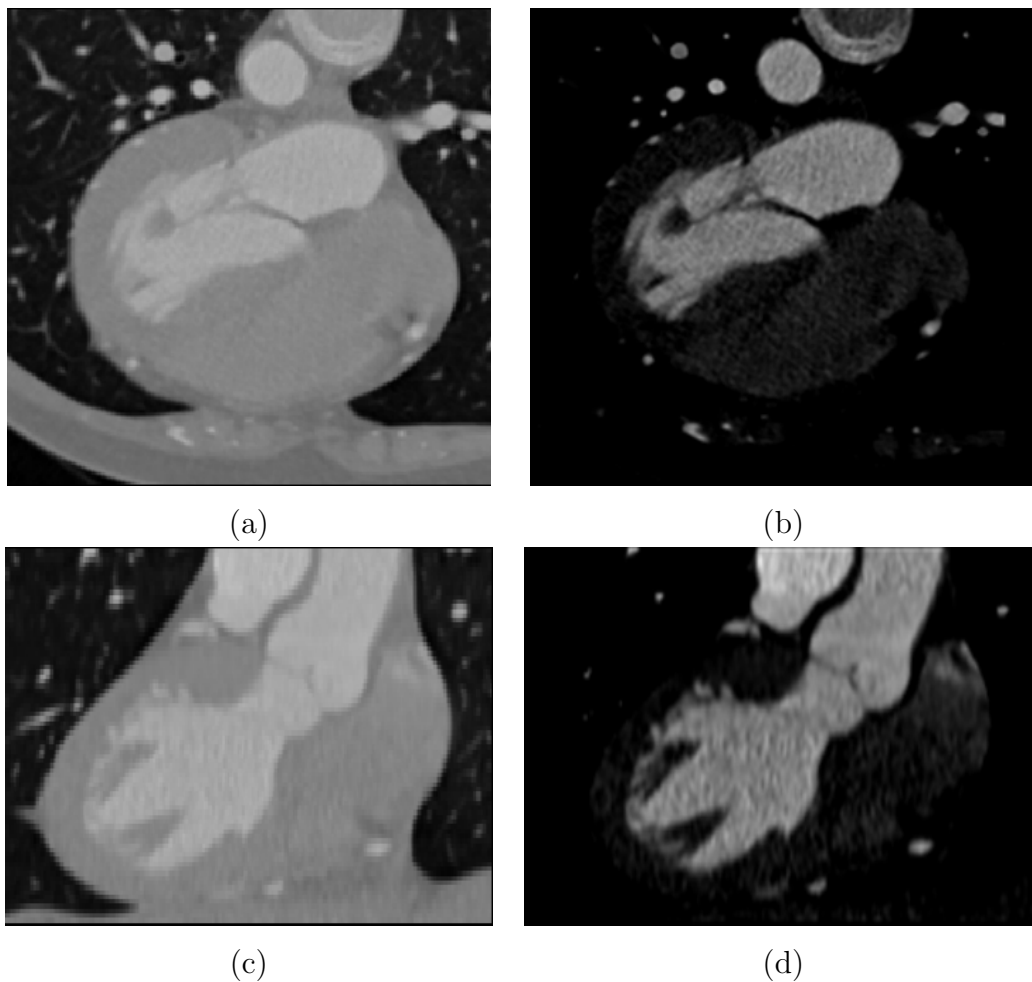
Example of an CTA image before and after pre-processing. (a) and (c): The original CTA image after contrast adjustment. (b) and (d): The post-processed CTA images showing better visibility of the coronaries.
